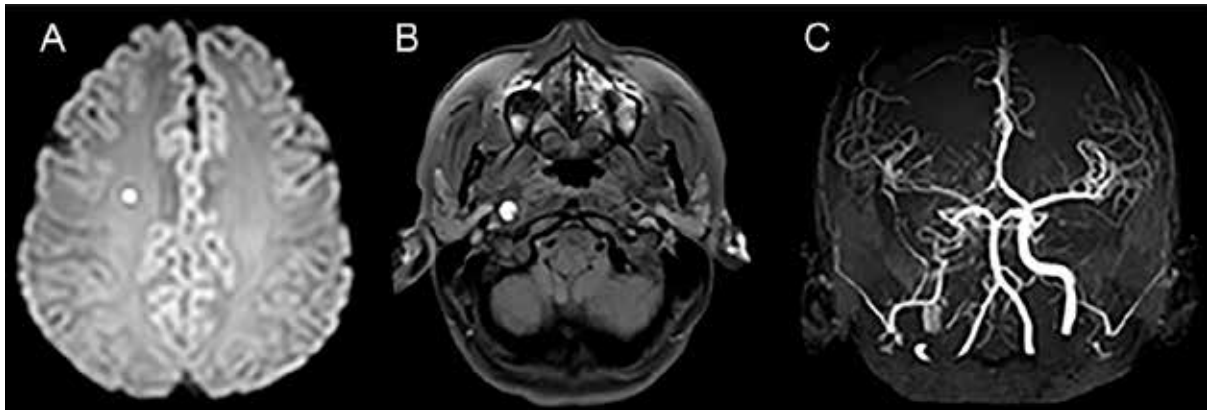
MRI and MRA imaging in the acute phase. A. DWI imaging revealing an acute stroke in accordance with the symptoms of the patient. B. STIR sequence showing dissection and wall hematoma in skull base. C. Time-Of-Flight imaging showing no flow in right internal carotid artery.
